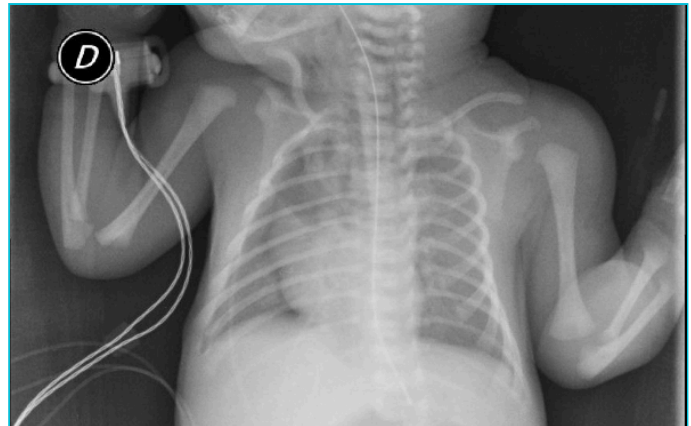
Chest x-ray. Bilateral pneumomediastinum, subcutaneous emphysema in the pharyngeal area, and an abnormal collection of air in the upper lobe of the right lung.
